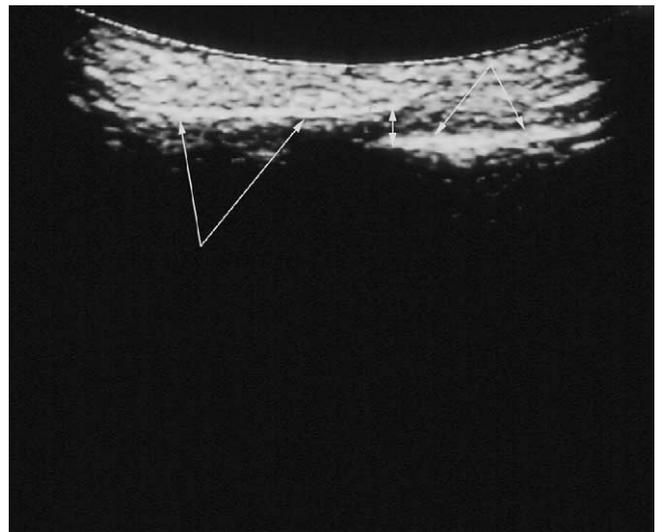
Ultrasound image of a lateral orbital wall fracture. The double arrow shows the dislocated fracture. The upper and lower arrows show the unfractured area of the lateral orbital wall.
